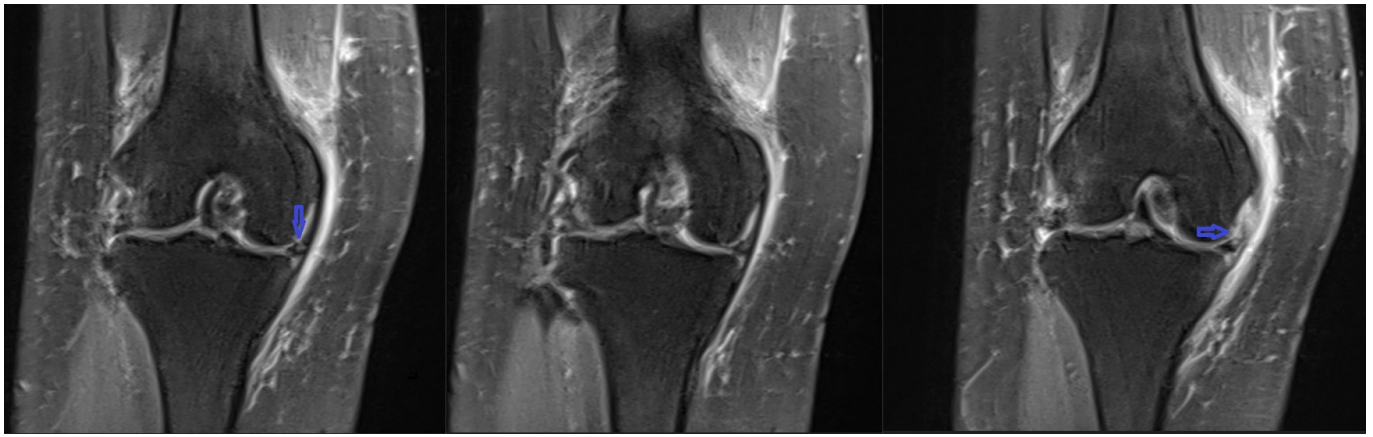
Abnormal band image (blue arrow) in the anteromedial region of the medial meniscus in the coronal planes on MR imaging, giving an appearance confusing with a meniscal tear.
